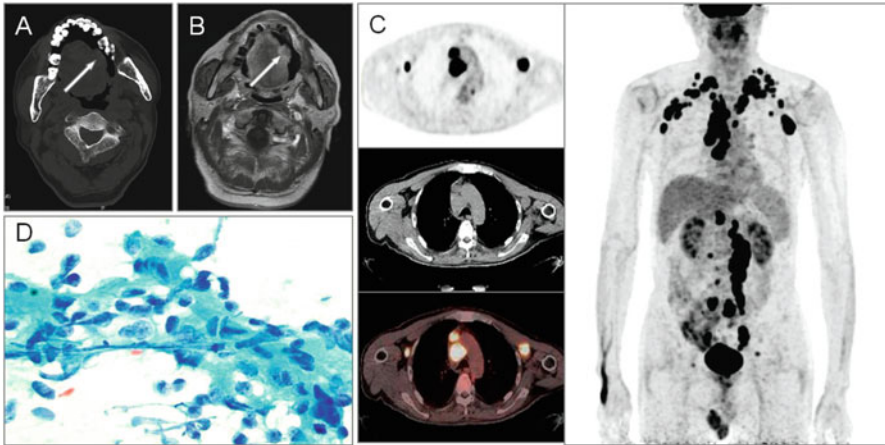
(a) CT imaging detected a mass located in the left edge of the tongue (*arrow*). (b) MR imaging revealed a mass with long T1 and long T2 signals on the left edge of tongue, a size of 20-mm*10-mm, ill-defined margins (*arrow*). (c) ^{18}F -FDG PET/CT imaging showed intensive FDG uptake in the left tongue (SUVmax = 13.83), clavicle and axillary lymph nodes (SUVmax = 16.26), mediastinum (SUVmax = 17.35), ventral prostate (SUVmax = 14.40 at 1 h and SUVmax = 20.46 at 2 h post ^{18}F -FDG injection), in retroperitoneum, bottom of mesentery, and left inguinal region's lymph nodes (SUVmax = 21.47). (d) Fine needle aspiration confirmed for squamous cell carcinoma
